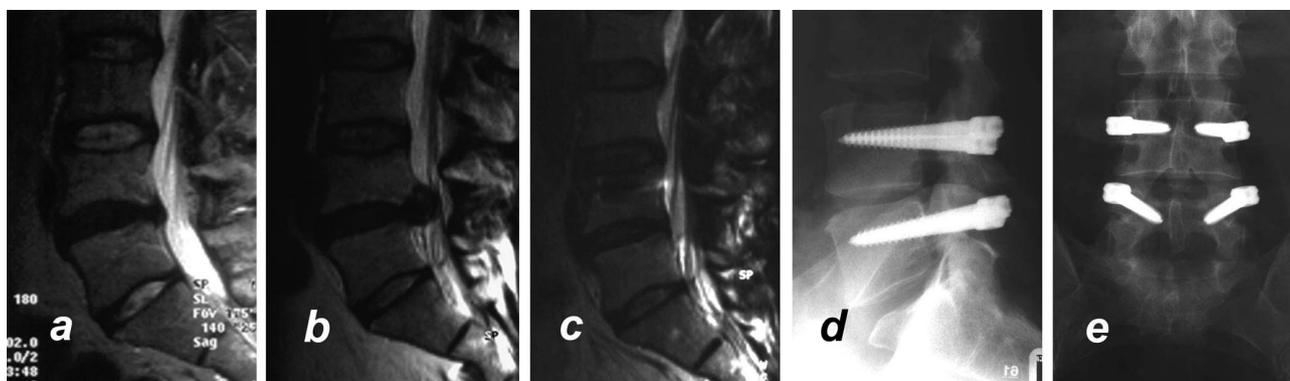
a-e, MRI after primary nucleotomy (a) and 14 months postoperative showing a large medial re prolapse L4/5 (b). Twenty-seven months after renucleotomy and DYNESYS stabilization (c-e), no progressive disc degeneration is seen. The 43-year-old male patient is very satisfied; sensorimotor deficits are no longer detectable.
